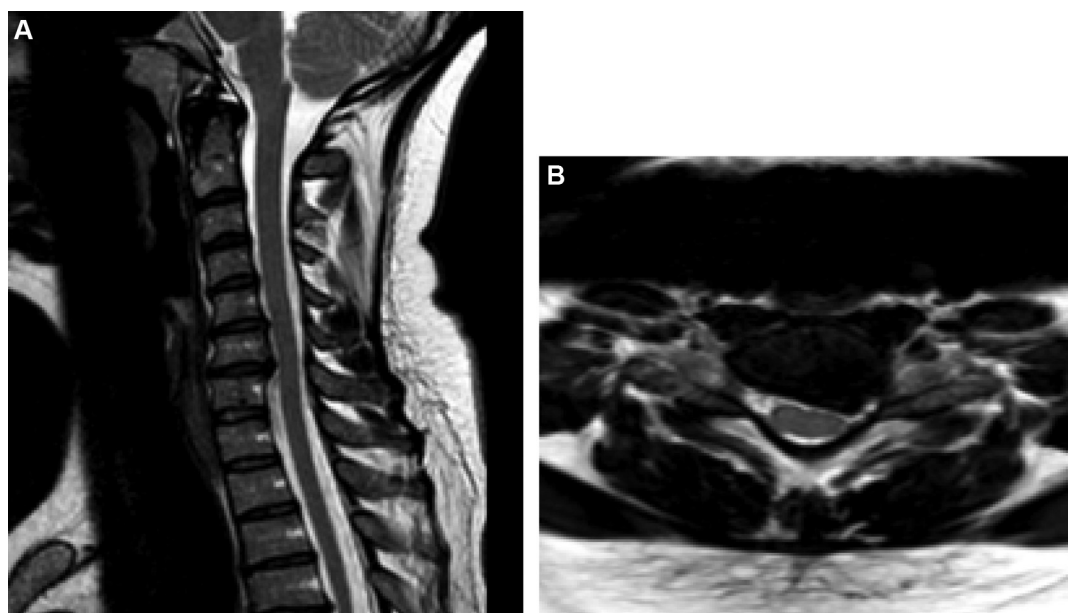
Preoperative MRI, T2-weighted sequence, after non-operative treatment: persistent C6–C7 left-sided disc herniation with no breach in the posterior longitudinal ligament. A. Sagittal view. B. Axial view
